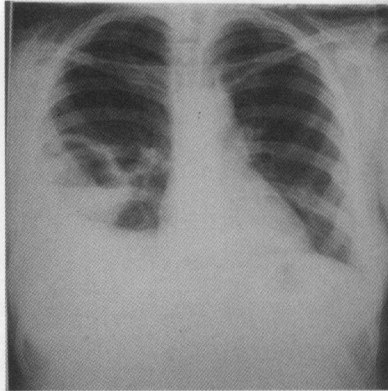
A single cavitory lesion in the middle lobe with a relatively thick wall and an air-fluid level can be seen in this posteroanterior chest X-ray of a 40-year-old female patient. A concomitant right-sided empyema is present.
